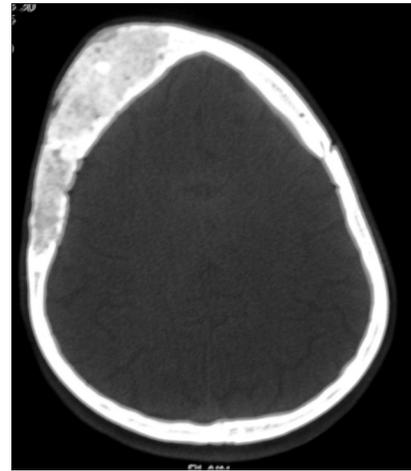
CT axial view showing ground glass appearance of the right temporal and frontal bones in a case of craniofacial fibrous dysplasia
